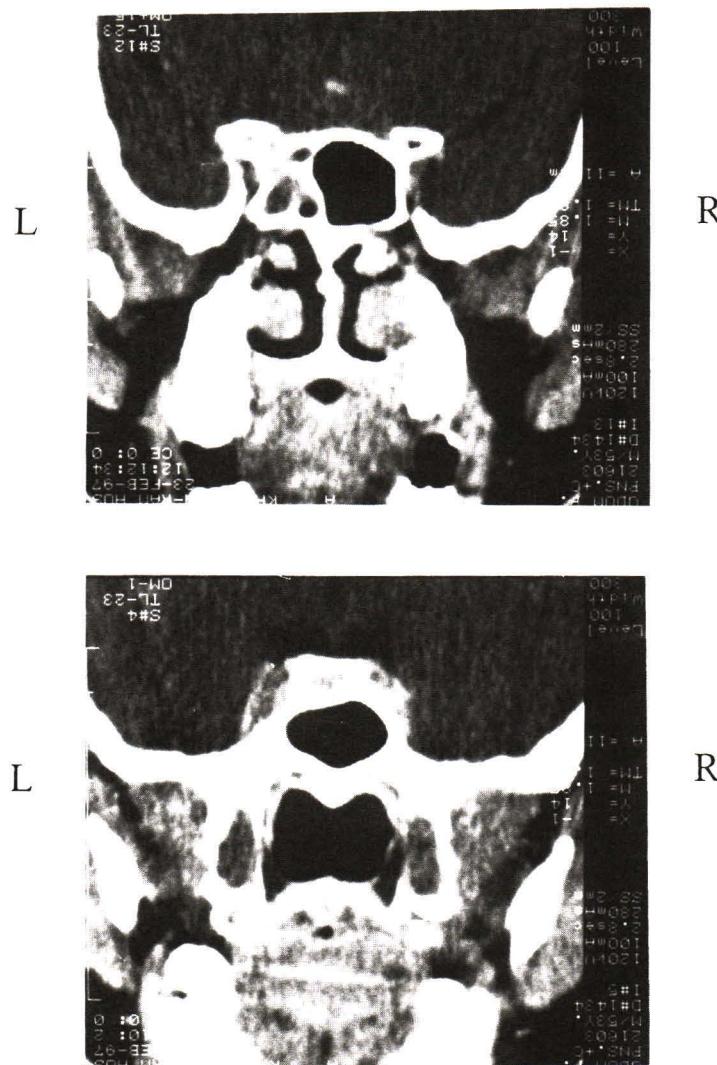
Coronal view of a computed tomography with contrast enhancement of the paranasal sinuses showed left sphenoid sinusitis with bulging of the lateral wall of the left cavernous sinus.
